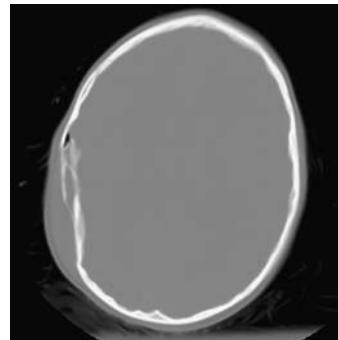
Pre-operative head CT scan (bone window) demonstrating a depressed skull fracture secondary to a golf club impact
